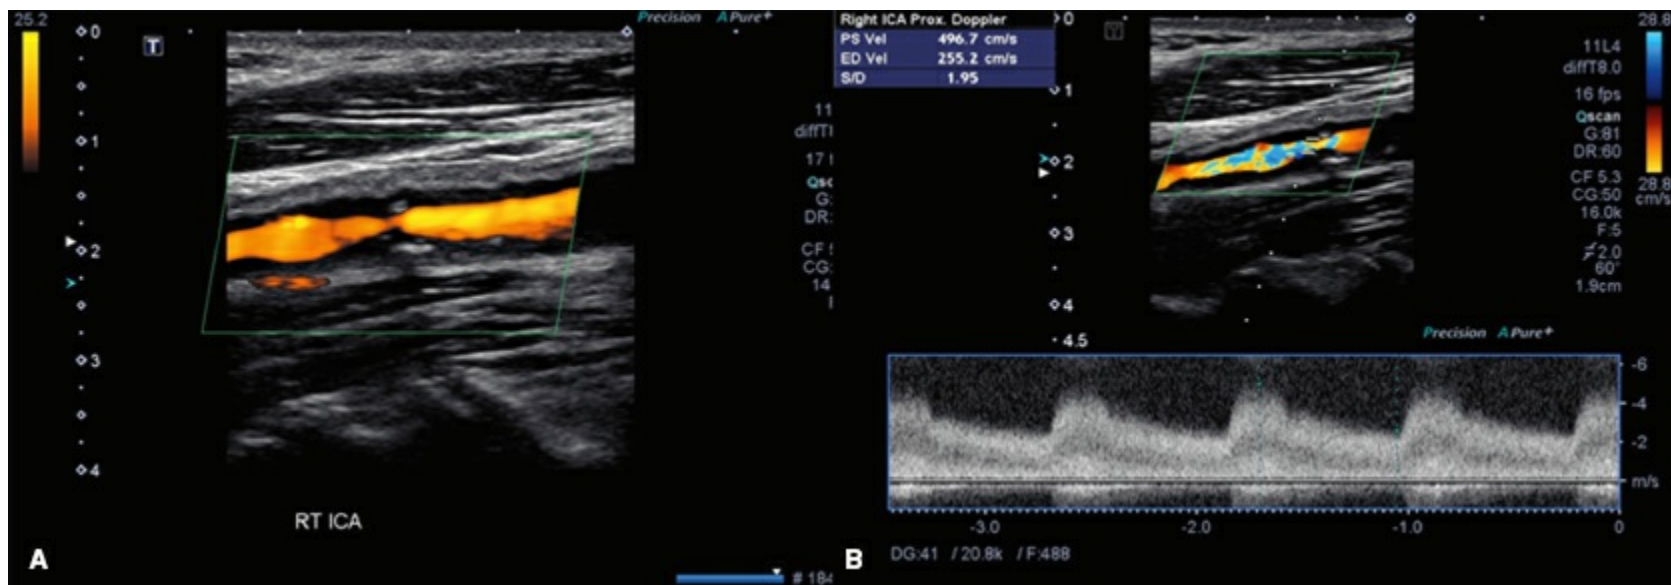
A: Color power Doppler shows a severe stenosis at the origin of the internal carotid artery. B: The peak systolic velocity is 497 cm/s, correlating to a >70% stenosis.
